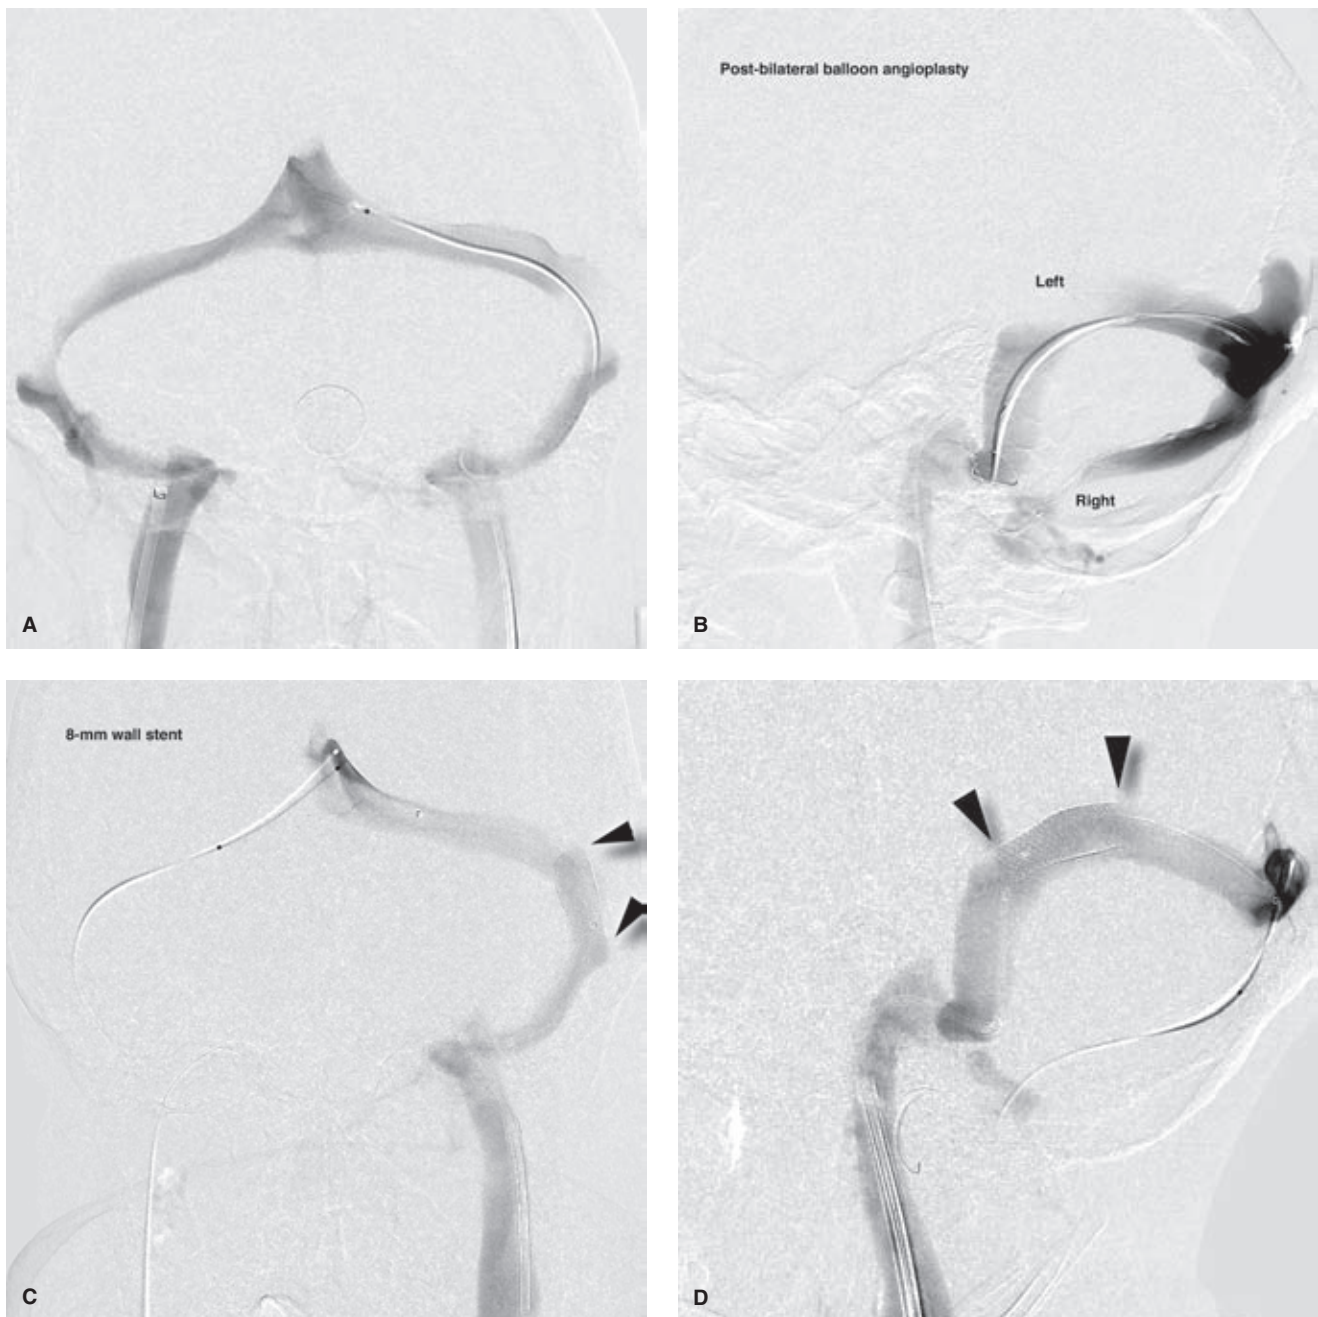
(A–F) Idiopathic intracranial hypertension refractory to medical therapy. This young adult female presented with intractable headaches and visual deterioration over a period of days. Her MRI and MRV (not shown) demonstrated marked bulging of the optic discs and bilateral narrowing of the transverse sinuses. Even on direct retrograde venography (A) the indentations on the course of the transverse sinuses bilaterally are subtle. The venous gradient across these regions was greater than 40 mm Hg and did not change post venous angioplasty with an 8-mm balloon (B). Notice in image (B) that skewing the lateral view allows a view of the transverse sinuses separated from one another. In images (C) and (D) an 8-mm Wallstent (*arrowheads*) has been placed in the left transverse sinus eliminating the appearance of compression of the sinus contour and also reducing the venous gradient to <10 mm Hg. (*continued*)
